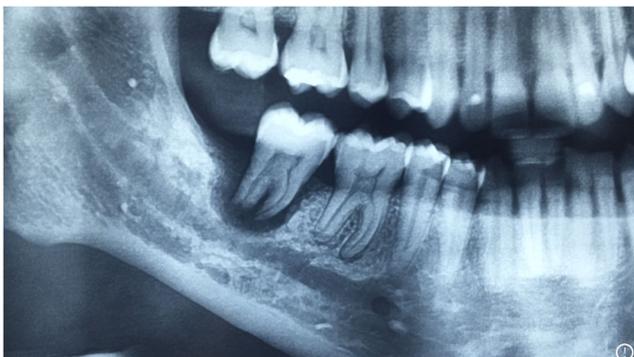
A radiograph showing a combined periodontal–endodontic lesion involving the second mandibular molar in a patient receiving anticoagulant therapy with a factor Xa inhibitor
